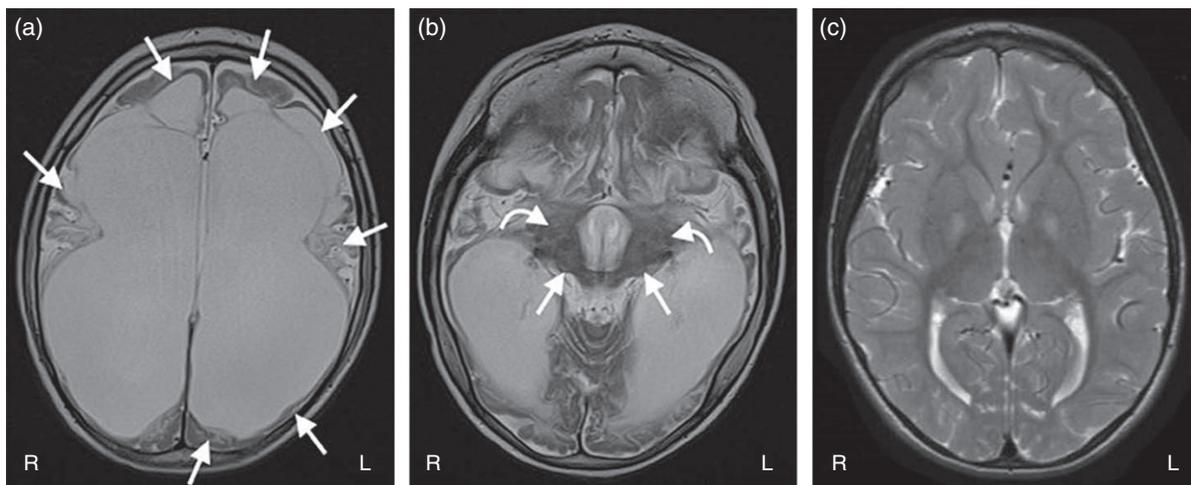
Severe grey matter injury. T2-weighted axial images demonstrating (a) severe bilateral cortical and subcortical cystic encephalomalacia (arrows) with secondary gross ex-vacuo dilatation of the lateral ventricles and (b) severe volume loss and gliosis of the thalami (straight arrows) and basal ganglia (curved arrows). (c) axial T2-weighted image demonstrates bilaterally symmetric, abnormal increased signal in the globus pallidi indicative of neonatal kernicterus.
